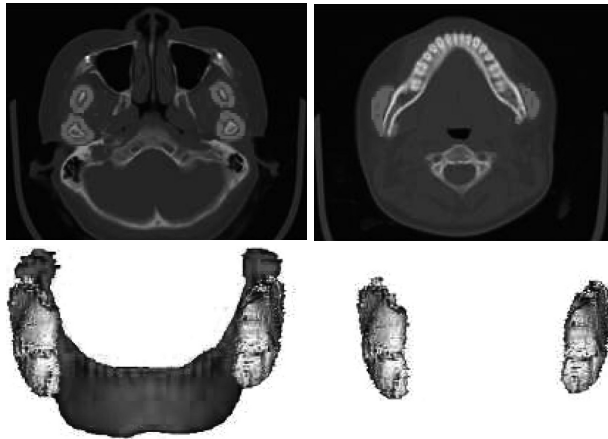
Image Segmentation Procedures. (Above) 2mm thickness, 512x512 pixels, axial CT image (Above, left) segmentation of mandible area from axial images including mandible bone (Above, right) segmentation of masseter area from axial images including masseter muscle (Below, left) 3D reconstructed mandible bone and masseter muscles image (Below, right) 3D reconstructed image of masseter muscles.
